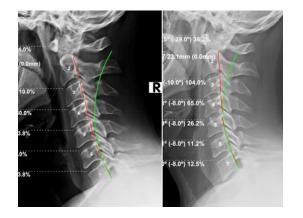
Lateral cervical radiographs. Left: Initial (8/28/17); Right: Follow-up (12/6/17). Green line indicates normal ideal cervical lordosis; red line highlights patient posterior vertebral body margins (CBP Seminars, Inc.).
